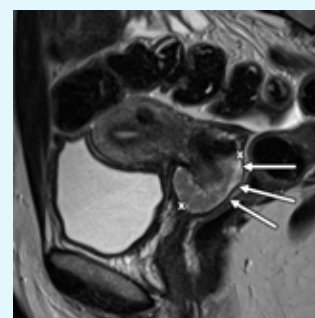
Sagittal T2-w MRI scan in a 46-year-old woman showing a 4.3cm cervical cancer (between callipers) protruding into the upper vagina (arrows); this is consistent with Stage IB3 disease.
